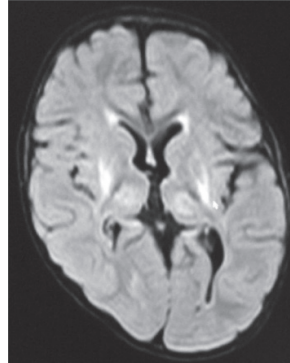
MRI brain shows FLAIR hyper intensities at bilateral putamen and bilateral thalami.
